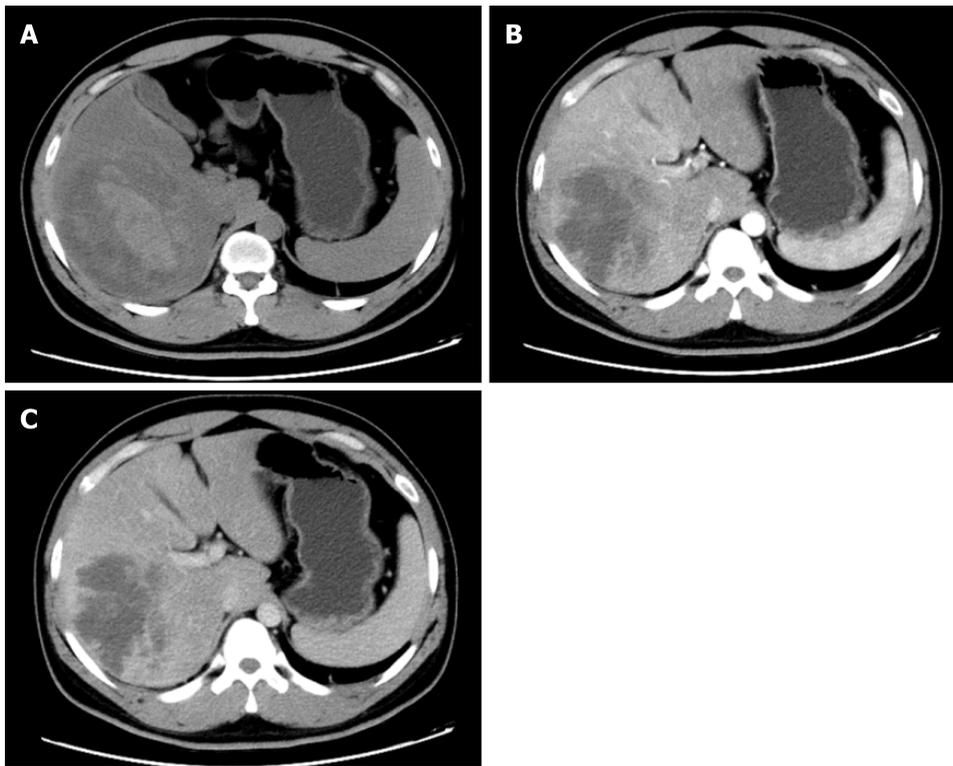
Computed tomography imaging of liver infarction. A: Plain scan phase of computed tomography (CT) detected an irregular lesion in the right lobe of the liver; B: Arterial phase of CT showed no obvious enhancement; C: Venous phase of CT showed no obvious enhancement.
